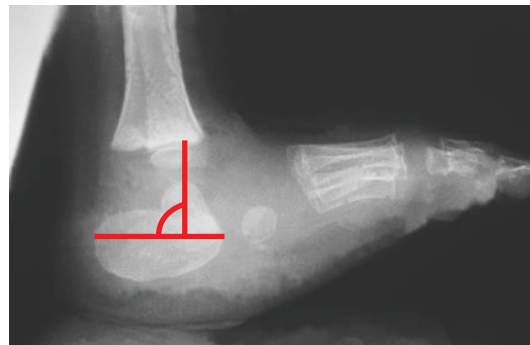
Lateral X-ray of a convex pes valgus. The longitudinal axis of the talus is more or less perpendicular to the axis of the calcaneus and that is why it is also called a talus verticalis
